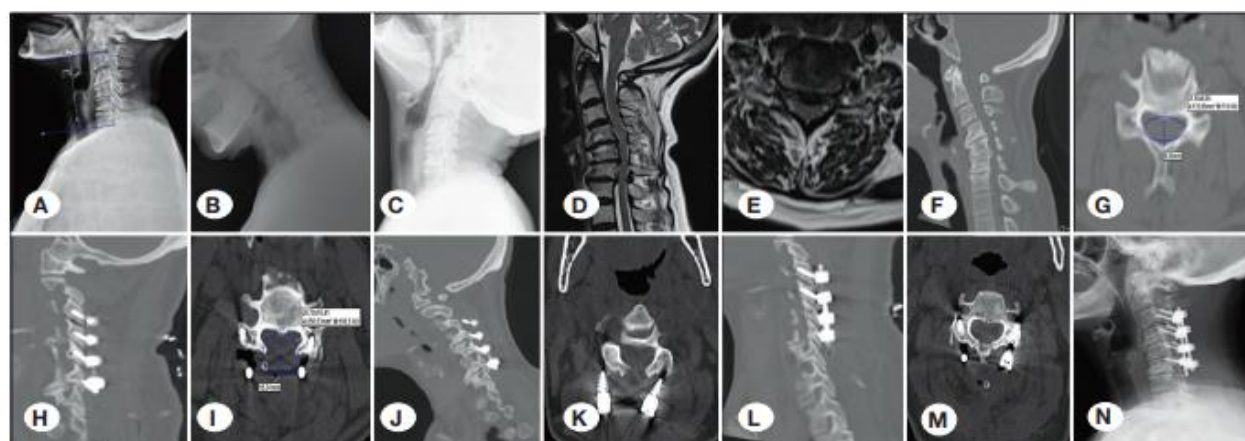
Preoperative radiographs (lateral cervical) (A) flexion; (B) extension (C) preoperative MRI (flexible kyphosis); (D) MRI, sagittal; (E) MRI, axial; (F) CT, sagittal; (G) CT, axial; (H) CT, sagittal; (I) CT, axial; (J) LF, sagittal; (K) LF, axial; (L) CT, sagittal (traffic accident of patient after one month of LF); (M) CT, axial and (N) x-ray, lateral
